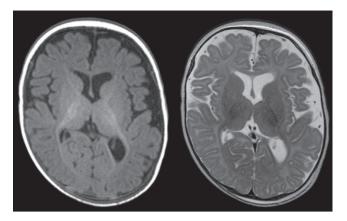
Brain magnetic resonance imaging at 4 months of age (left: T1 weighted image, right: T2 weighted image). White matter volume is moderately decreased.
